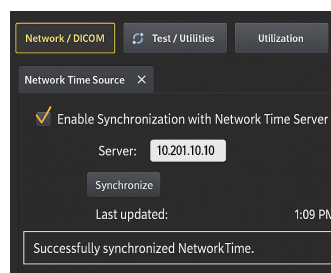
Configuration interface showing the ultrasound device set to synchronize its internal clock with the hospital's central time server configuring the *Network Time Source* setting.
